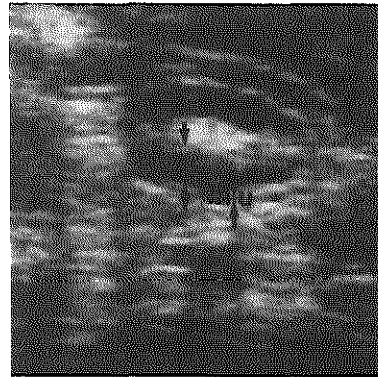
D. Transverse ultrasound scan of canine bowel *in vivo* surrounded by formaldehyde; hypoechoic bands represent mucosa (m) and muscularis (mu).
